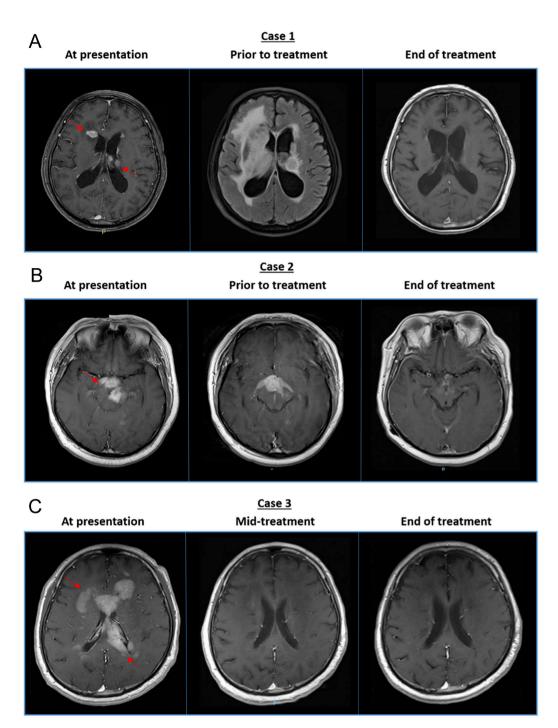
T1-weighted MRI images reveal the anatomical involvement of PCNSL at various junctures of treatment. (A) Complete responses to chemotherapy were observed in case 1, (B) partial response to chemotherapy was observed in case 2 and (C) complete responses to chemotherapy were observed in case 3. The red arrows indicate the initial sites of disease. PCNSL, primary CNS lymphoma.
